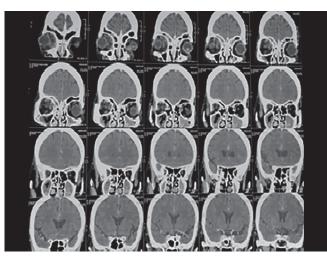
Computed tomography showing pansinusitis involvement
